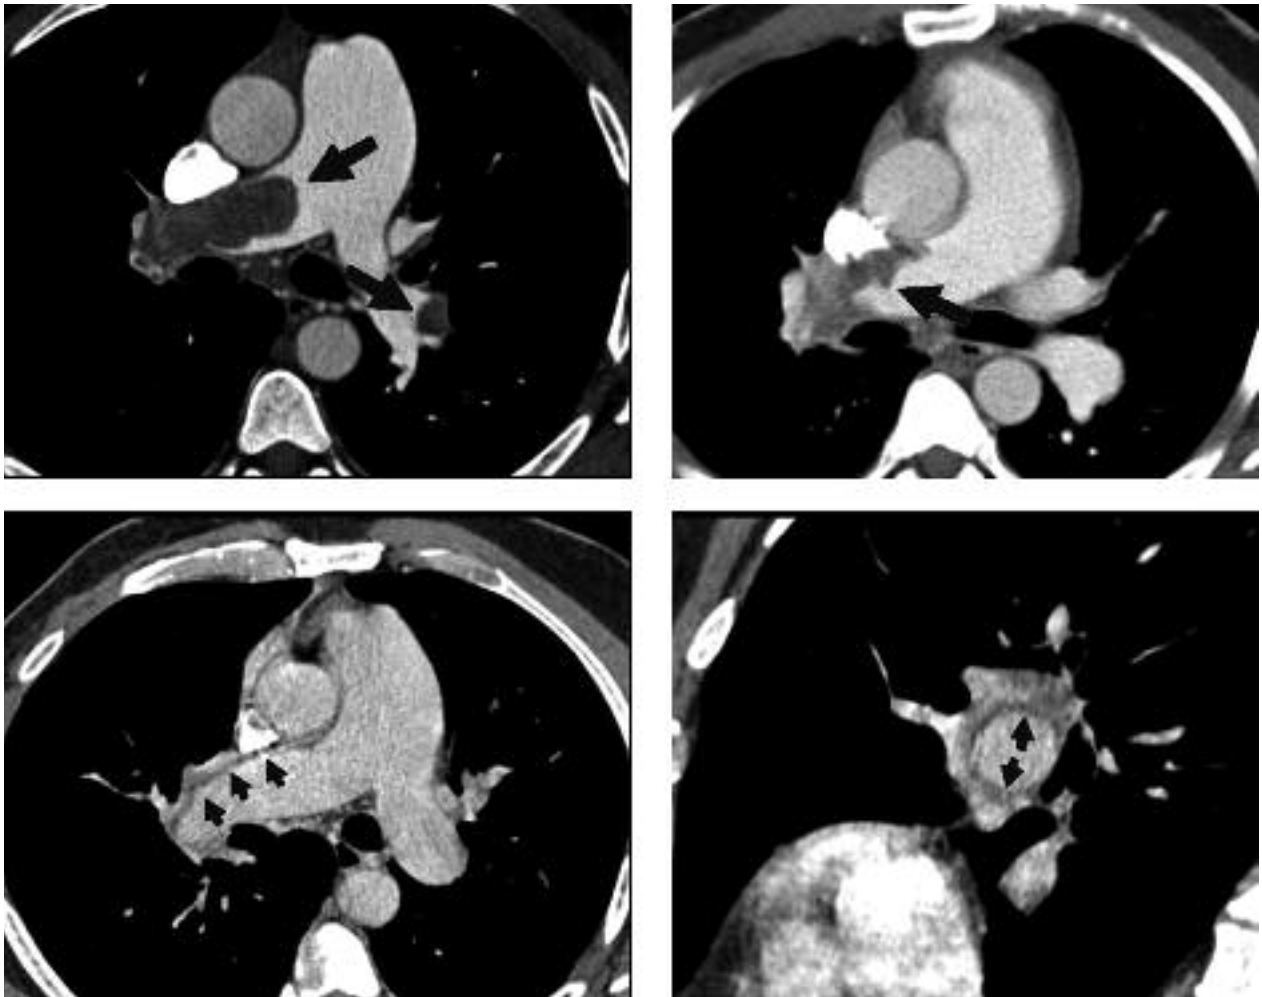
CT from the standpoint of angiographic recanalization of the pulmonary vessels with evidence of thrombotic stratification to vascular wall, reducing the diameter of the pulmonary trunk
